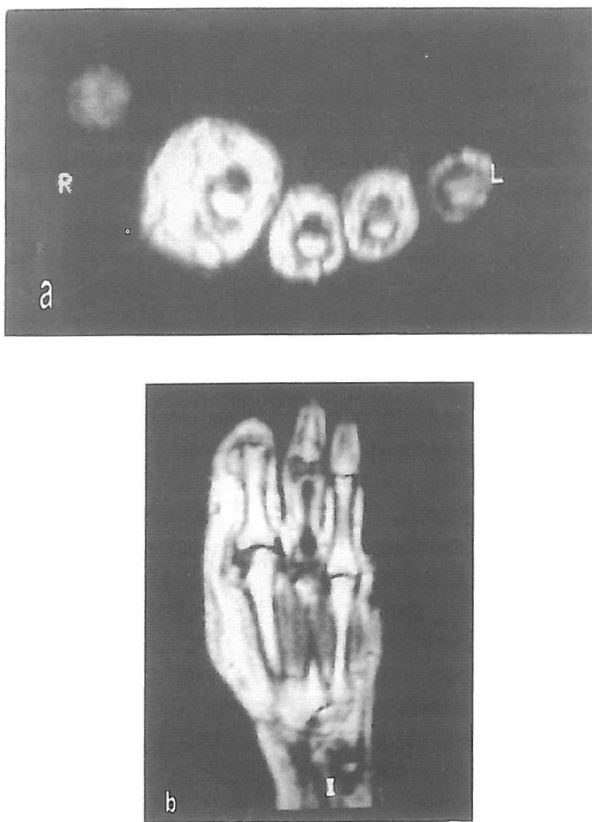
Axial (a) and coronal (b) T1 MRI FSE images demonstrate fatty hypertrophy around the index and less around the middle finger, without evidence of a capsule. No increased intensity in T2 images noted.
